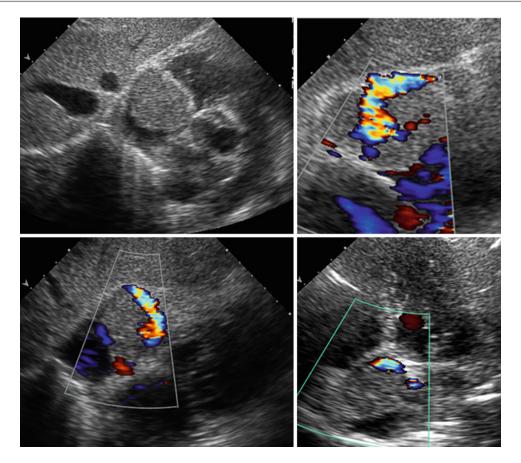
Transthoracic color-Doppler echocardiography. Reprinted with permission of the Italian Society of Cardiology. Richly vascularized right atrial paraganglioma
